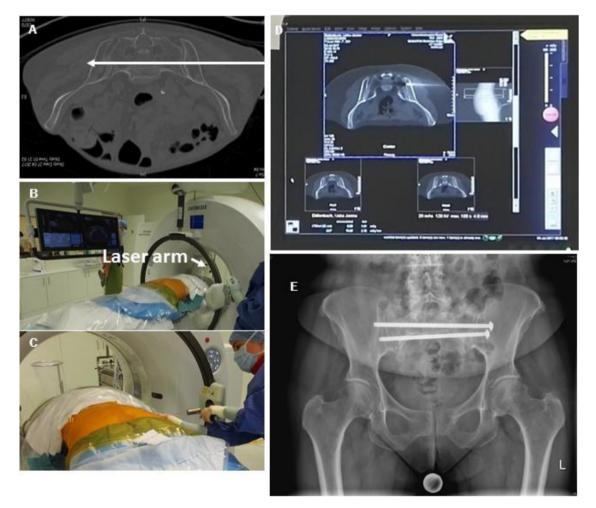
(A) Planning of the screw trajectory on axial images. (B) Patient in prone position. The planned entry point is projected on the skin using a laser pointer on the arc. (C) Introduction of a Kirschner-wire with hammer or drill. (D) Introperative control of the wire position during insertion with a low-dose scan resulting in 3 images with 4.8 mm distance. (E) Radiograph of the pelvis after insertion of 2 trans-sacral 7.3 cannulated screws.
